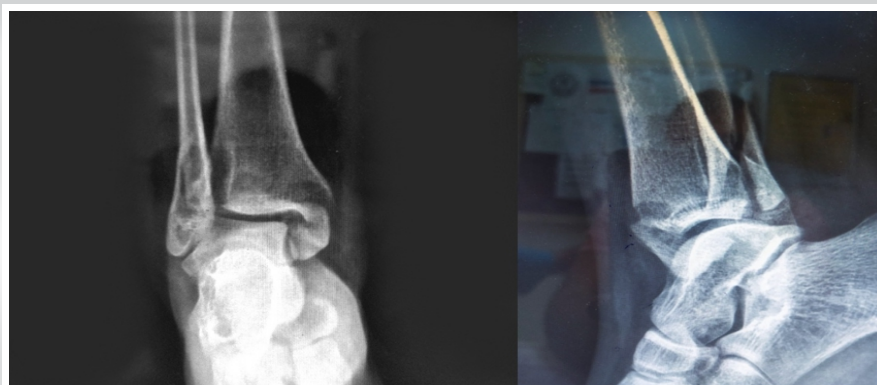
Emergency admission ankle anteroposterior and lateral radiographs of a 42-year-old patient with a trimalleolar fracture.
